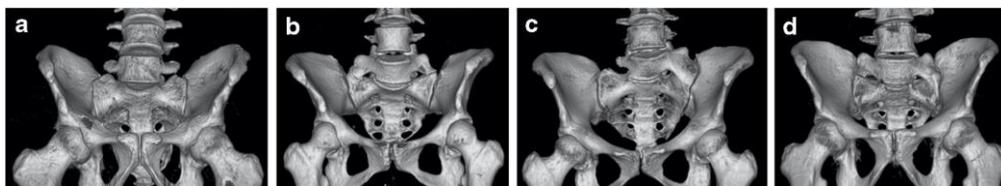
CT scans of different LSTV types in our patient population. a. Castellvi Ib, b. Castellvi IIb, c. Castellvi IIIa, d. Castellvi IV. CT = computed tomography, LSTV = lumbosacral transitional vertebrae
